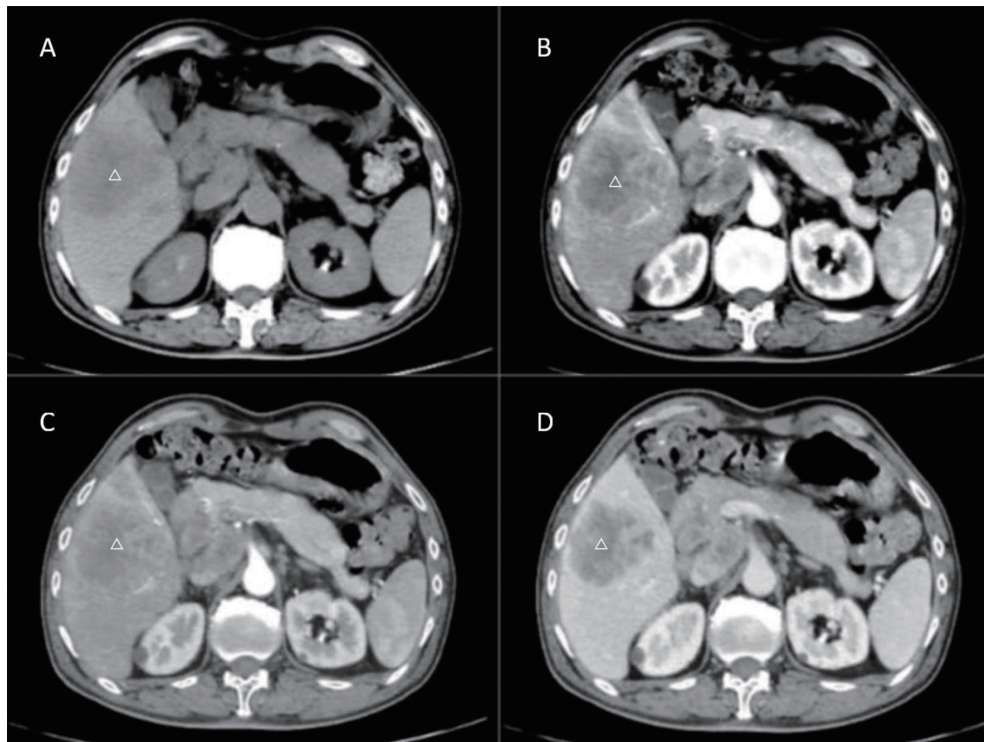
Figure 2. A chHCC-CCA lesion as shown on CT. A low-density lesion on non-contrast images (A) and a heterogenous enhancement pattern in the nodule in the arterial phase (B). The enhancement of the lesion is persistent on the portal (C) and delayed phase (D). chHCC-CCA, combined hepatocellular cholangiocarcinoma; CT, computed tomography.
